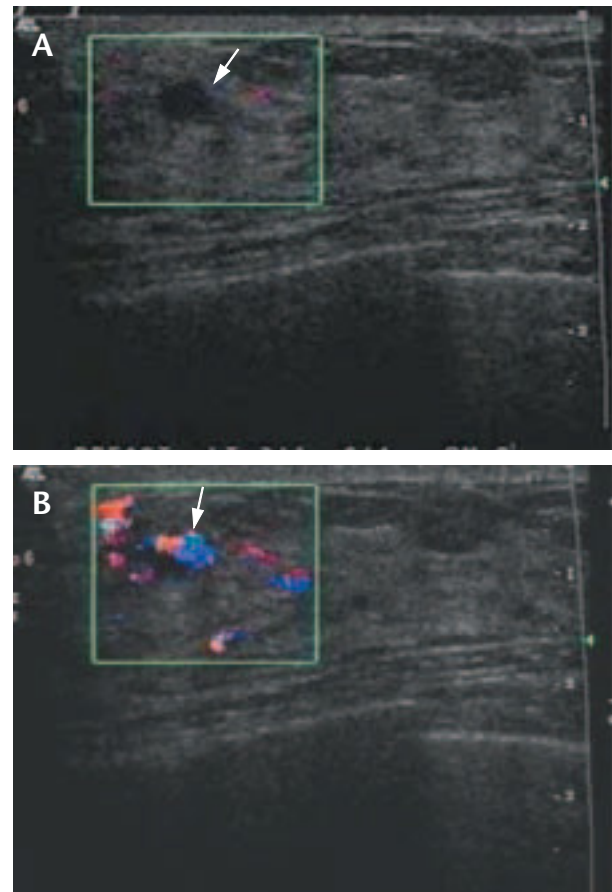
A small intraductal papilloma ( $0.8 \times 0.6$  cm) (arrowhead) and a dilated duct (arrows) are shown on color Doppler ultrasound; the color flow signals in the lesion are indicative of a solid tumor or a papilloma.
